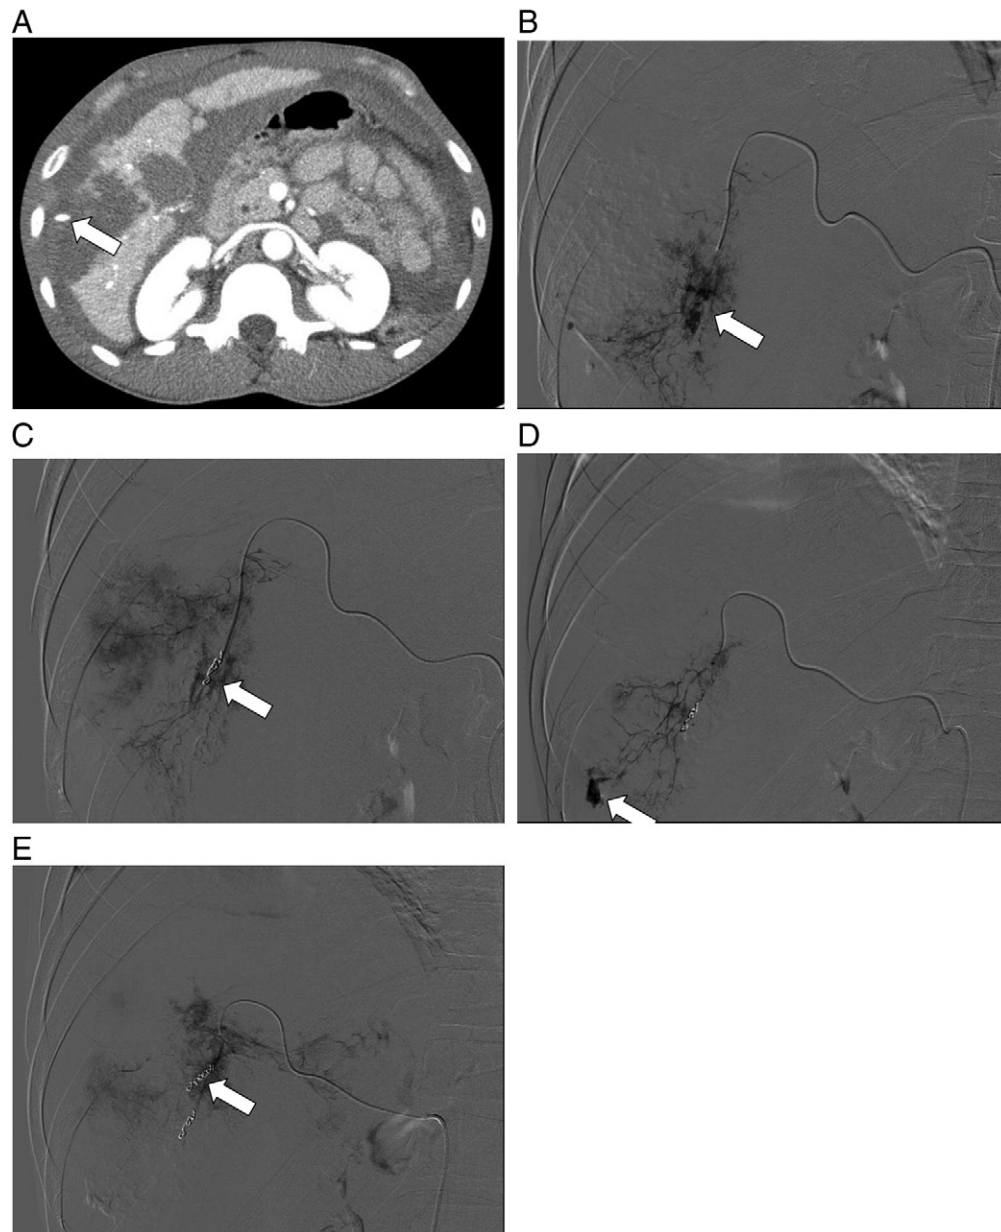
(A) Post liver biopsy CT showing hemoperitoneum with active arterial extravasation near the biopsy site (arrow); (B) Diagnostic angiogram shows one site of hemorrhage (arrow); (C) Angiogram following highly selective embolization with the deployment of platinum coil (arrow) shows no sign of hemorrhage; (D) Diagnostic angiogram shows additional site of hemorrhage (arrow); (E) Angiogram following highly selective embolization with the deployment of additional platinum coils (arrow) shows no sign of hemorrhage.
